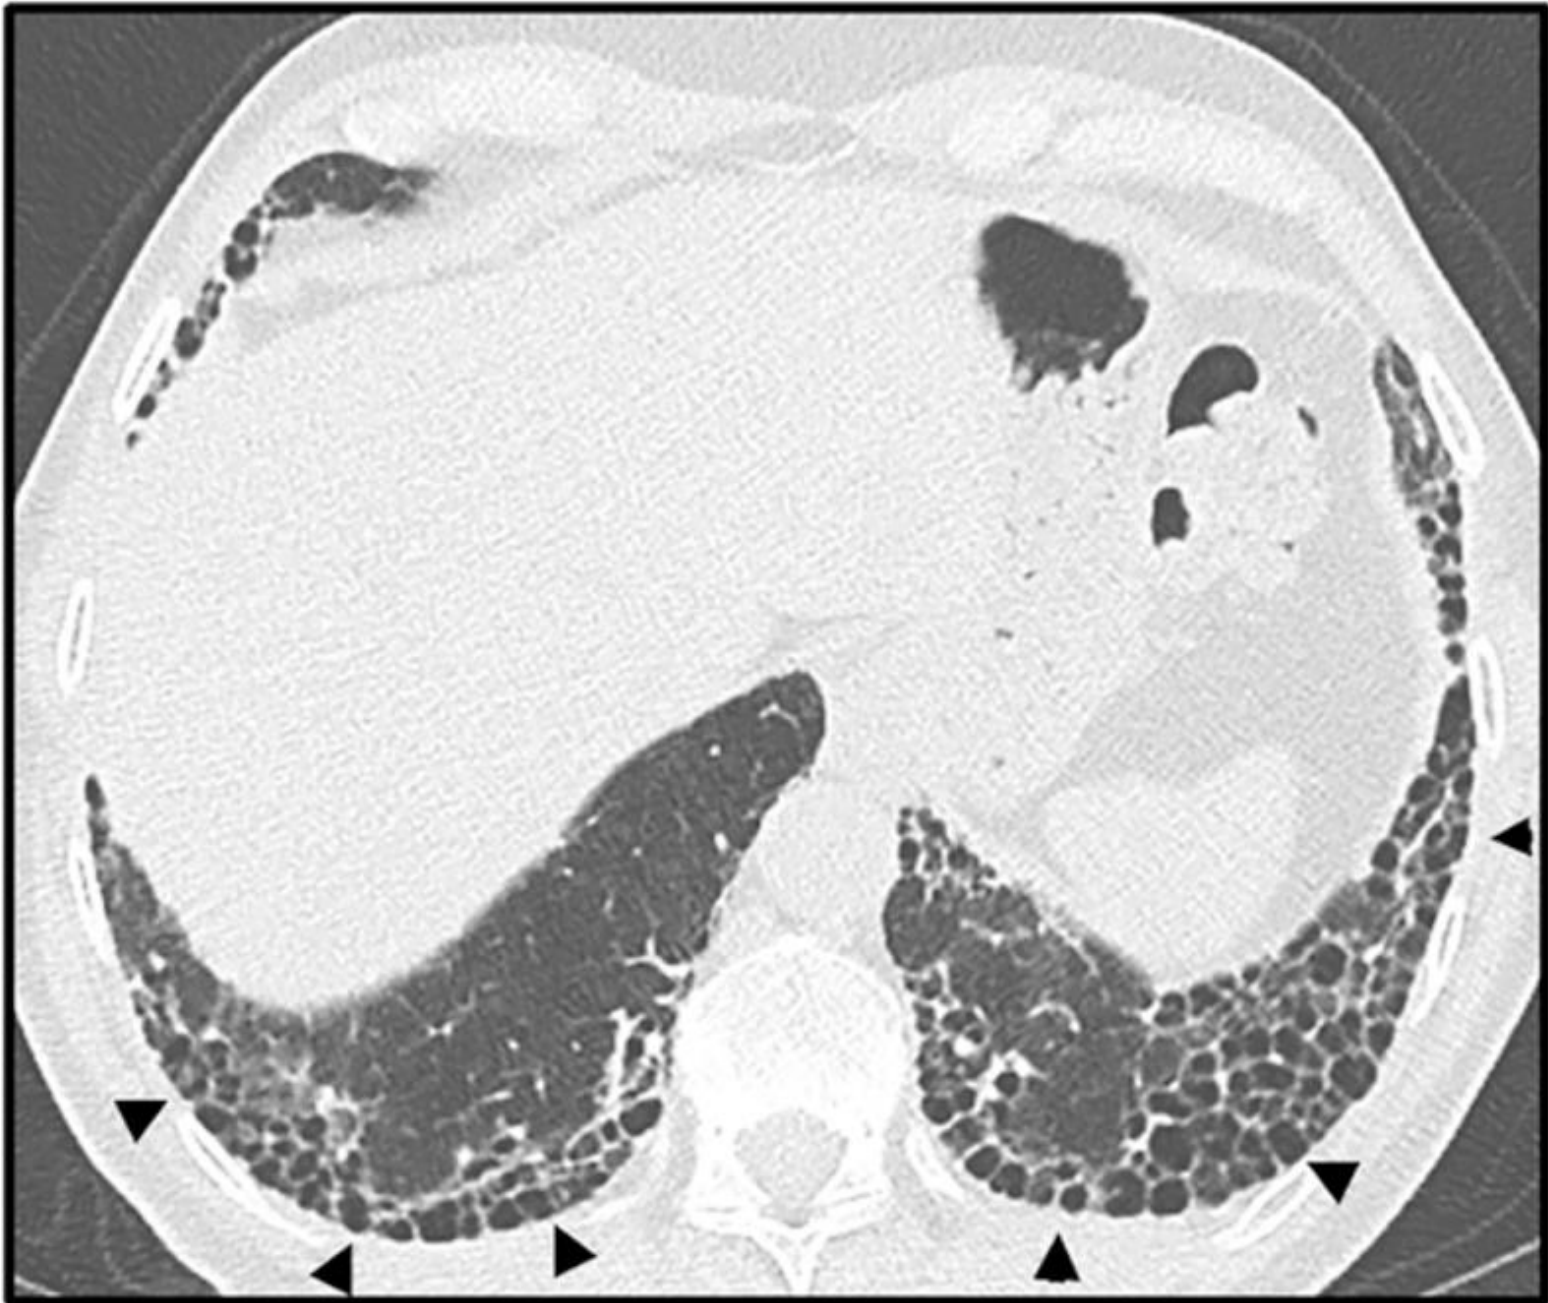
Honeycombing. Axial, sagittal, and coronal computed tomography images show subpleural-predominant, lower lung-predominant reticular abnormality with honeycombing (arrowheads). Honeycombing is defined by clustered, thick-walled, cystic spaces of similar diameters, measuring between 3 and 10 mm but up to 2.5 cm in size. The size and number of cysts often increase as the disease progresses. Often described in the literature as being layered, a single layer of subpleural cysts is also a manifestation of honeycombing. Honeycombing is an essential computed tomography criterion for typical ("definite") usual interstitial pneumonia-idiopathic pulmonary fibrosis pattern when seen with a basal and peripheral predominance. In this pattern, honeycombing is usually associated with traction bronchiolectasis and a varying degree of ground-glass attenuation.
